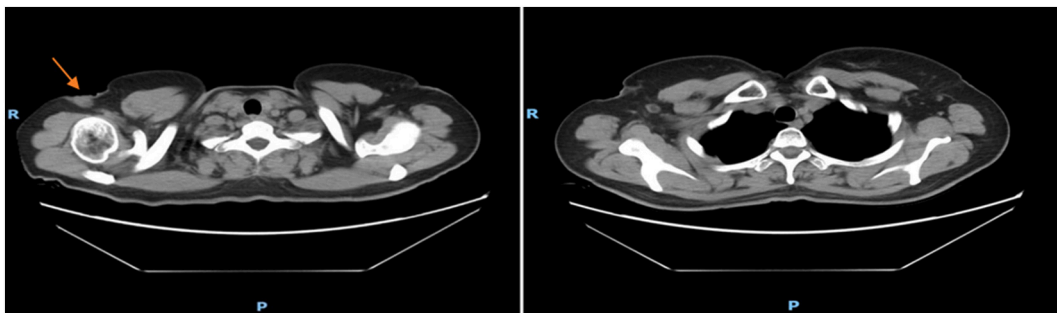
CT scan with axial cuts showing a subcutaneous axillary mass (arrow) of 2.3×1.3 cm associated with few axillary lymph nodes.
